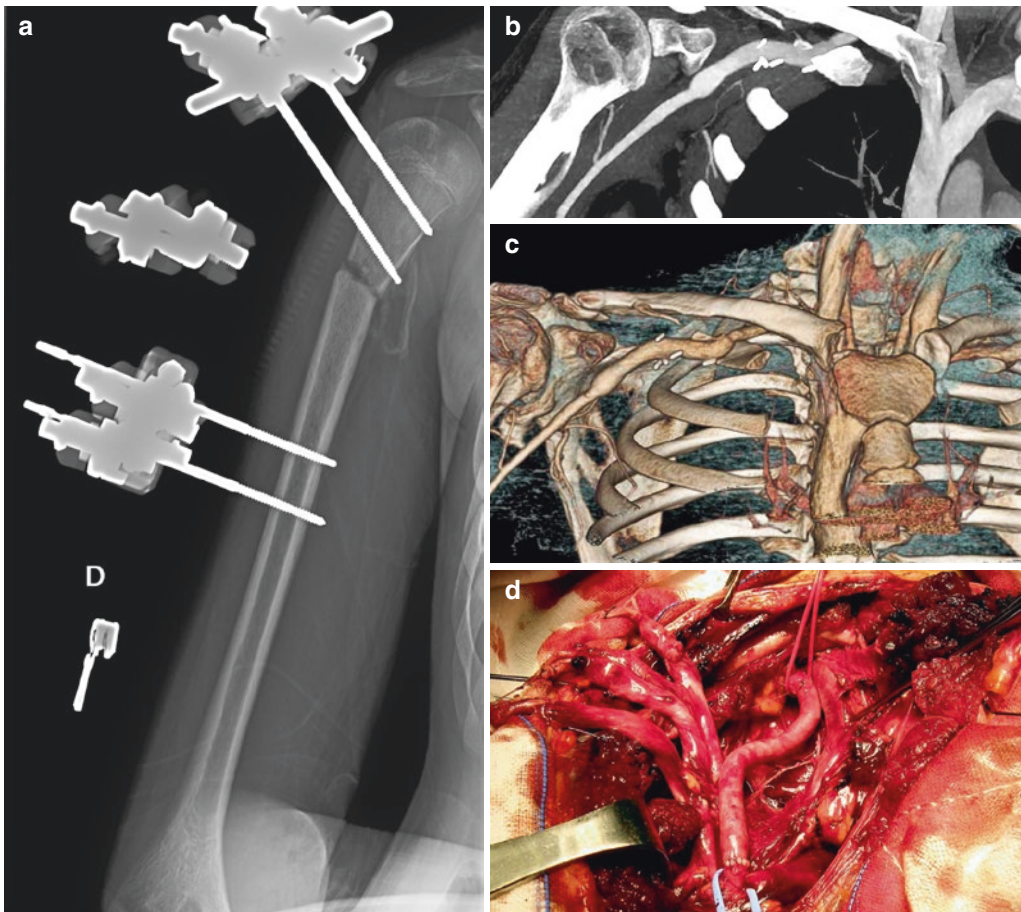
Humeral X-ray after external fixation in the same patient (a). MIP (b) and VR reconstruction (c) of the subclavian and axillary artery after surgical repair. Surgical imaging of vascular reconstruction with saphenous vein stent graft of the axillary artery (d). Courtesy of Professor Seccia
